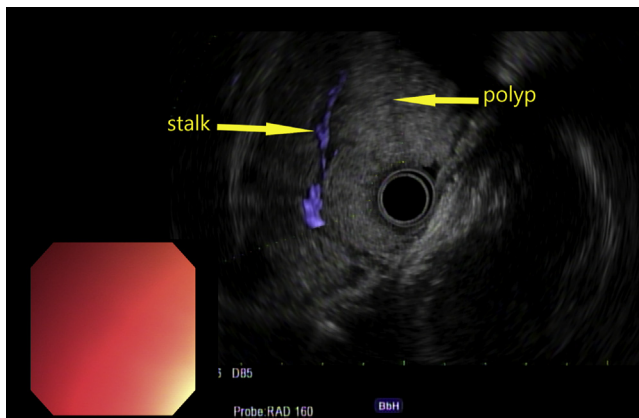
EUS image of the polyp stalk arising from the submucosal layer, with Doppler flow indicating significant vascularity in the polyp stalk.
